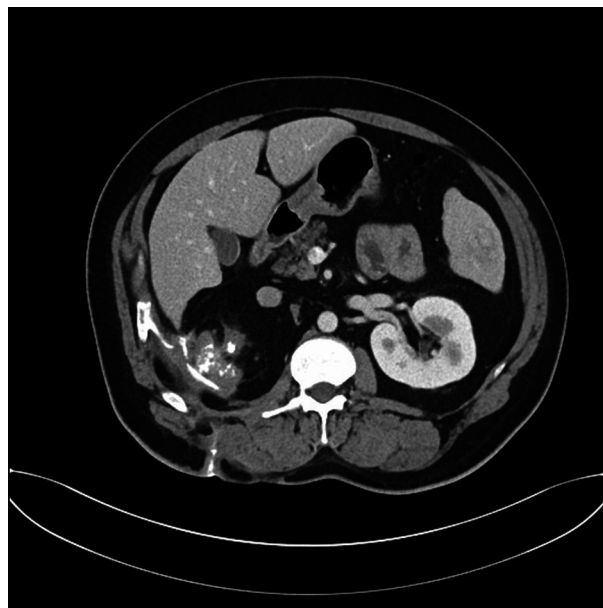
CT Scan Demonstrating an Area of Soft-Tissue Appearance That Implies Right Autonephrectomy, as Well as the Fistula Tract Between the Skin and Retroperitoneal Space
